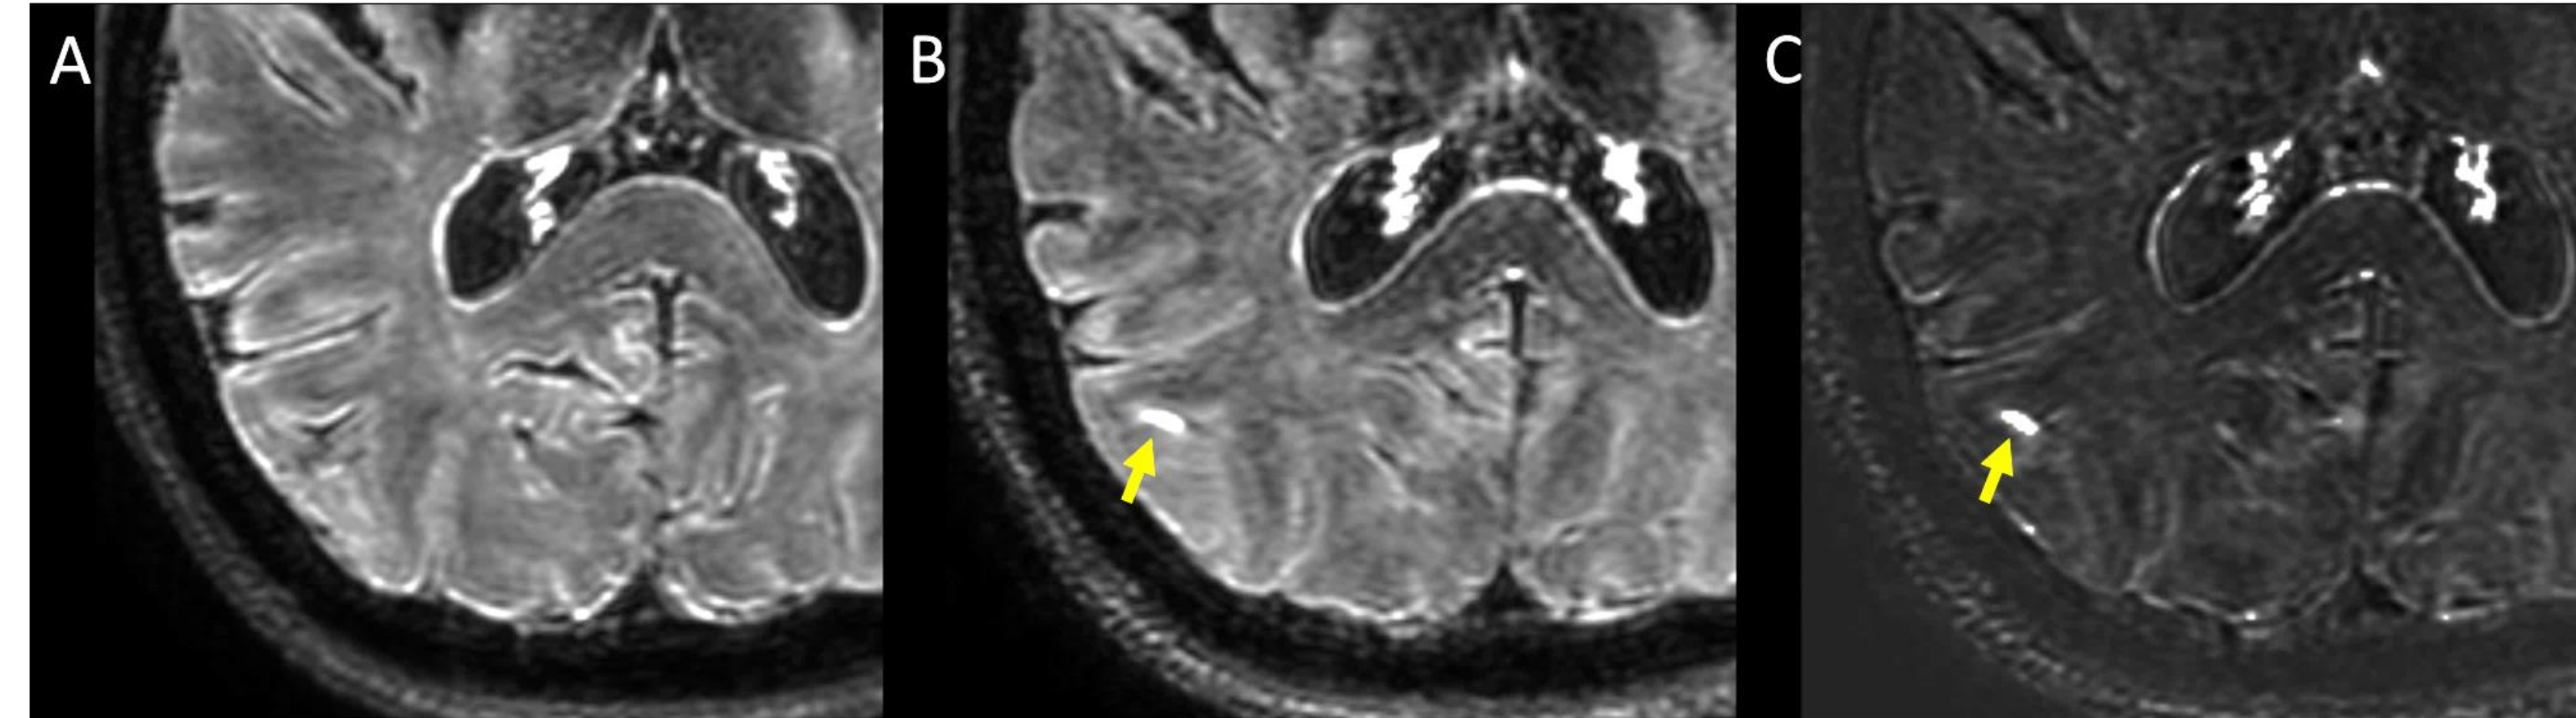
Process for identification of LME. Shown is an example of leptomeningeal enhancement (LME, yellow arrow). To identify such foci, co-registered pre-Gd FLAIR (A), Gd+ FLAIR (B), and subtraction (Gd+ minus Gd- (C)) were reviewed. Regions of hyperintensity on subtraction maps were confirmed on anatomic images and labelled as LME if present in the leptomeninges (pia, subarachnoid).
